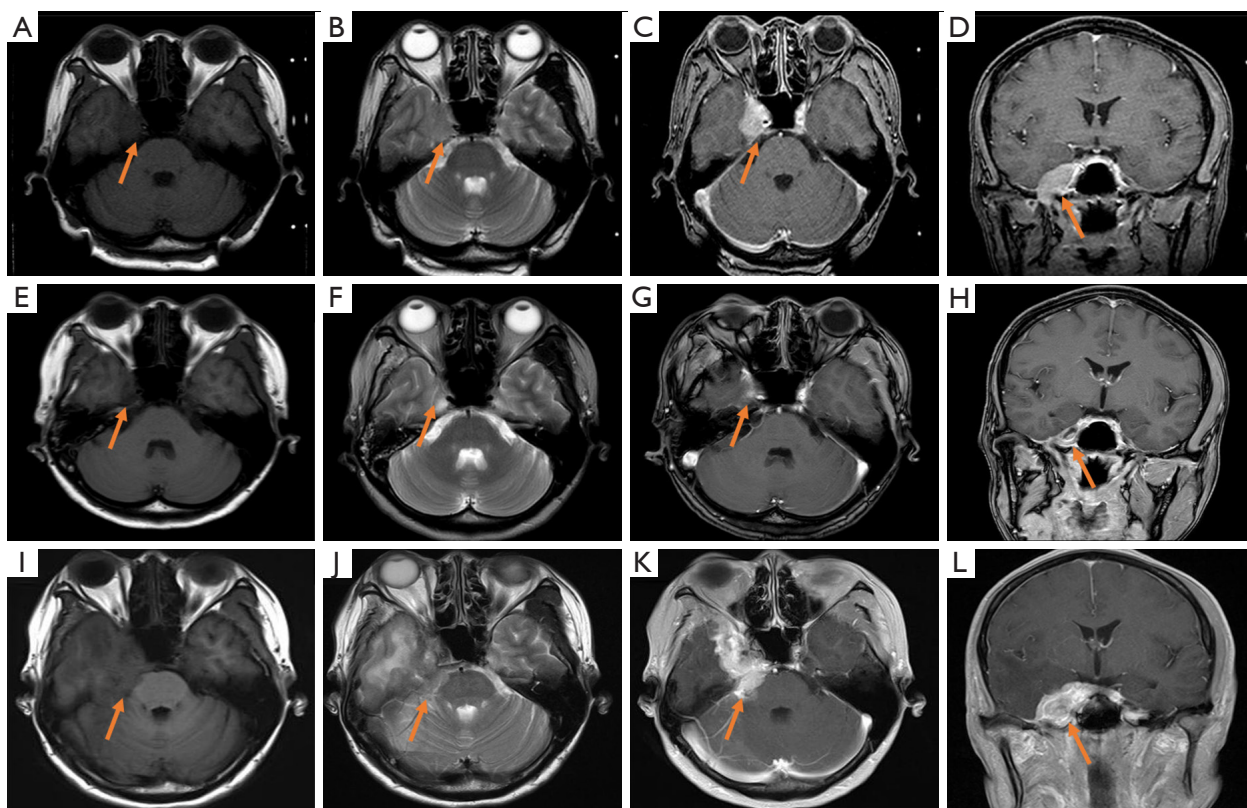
MRI findings of the lesion. (A-D) MR images showed a lesion in the cavernous sinus enveloped the internal carotid artery and locally extended to the parapharyngeal space via the foramen ovale before gamma knife treatment. (E-H) MR images showed the lesion was significantly reduced after gamma knife treatment. (I-L) MR images showed a recurrent lesion before craniotomy. (A,E,I) MRI showed an isointense lesion on T1-weighted imaging (arrows). (B,F,J) MRI showed an isointense lesion on T2-weighted imaging (arrows). (C,G,K) MRI showed a hyperintense mass on axial enhanced T1-weighted imaging (arrows). (D,H,L) MRI showed a hyperintense mass on coronal enhanced T1-weighted imaging (arrows). MRI, magnetic resonance imaging.
